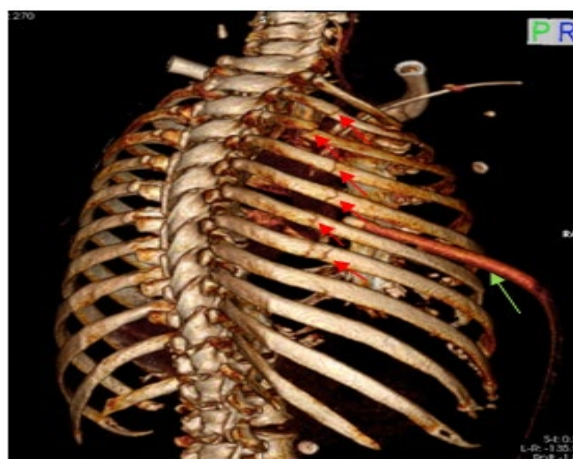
3-D reconstruction CT thorax showing Right posterior 2nd-7th ribs fracture (red arrow) and tube thoracostomy in situ (green arrow)
